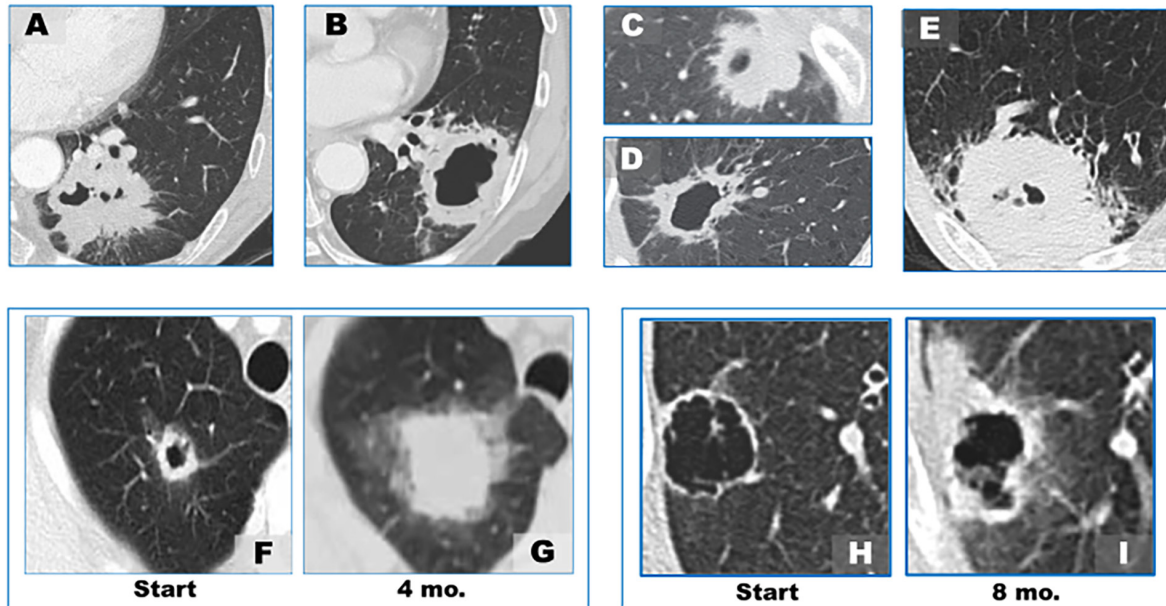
Representative CT images of progression of cystic LCAL.
